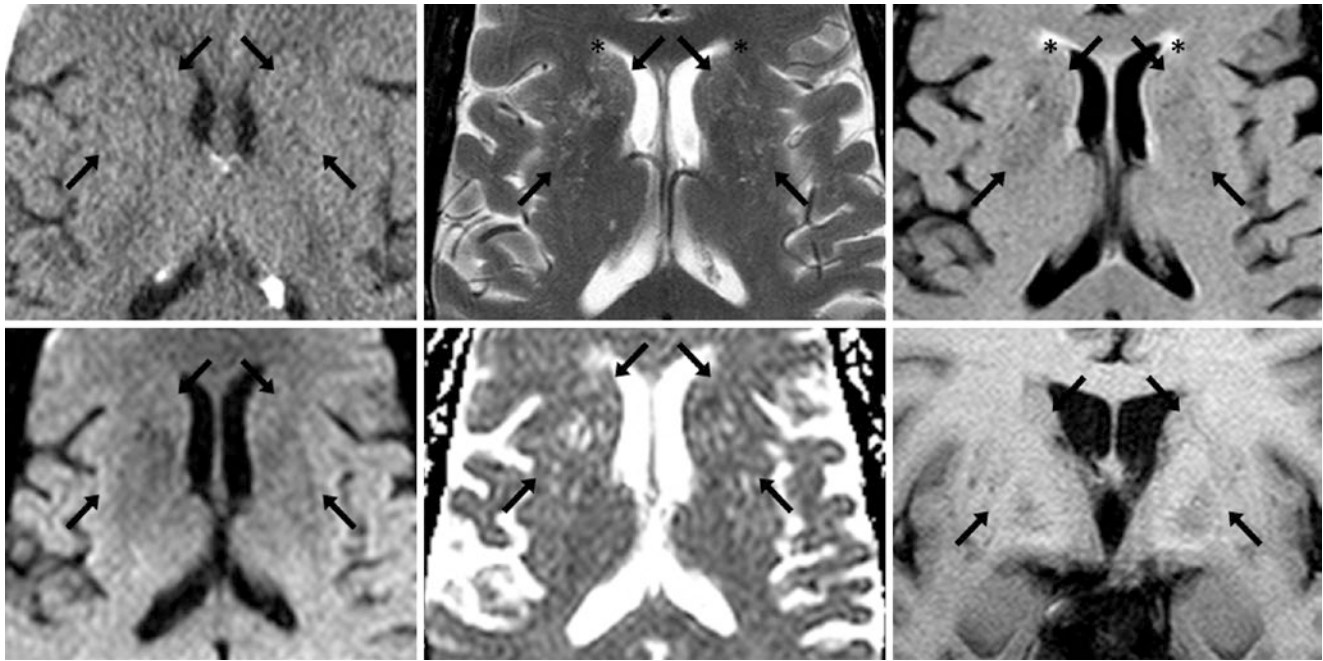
A 76 year old had bilateral cribriform-appearing basal ganglia PVSS (i.e., *état criblé* between arrows) on NECT (top left), T2WI (top middle), FLAIR (top right), DWI (bottom left), ADC map (bottom
